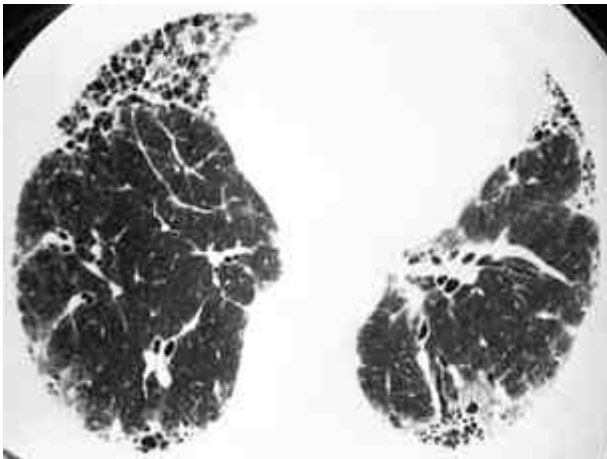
High-resolution CT of a 83-year-old man with rheumatoid arthritis shows microcystic pattern mainly at subpleural area.
